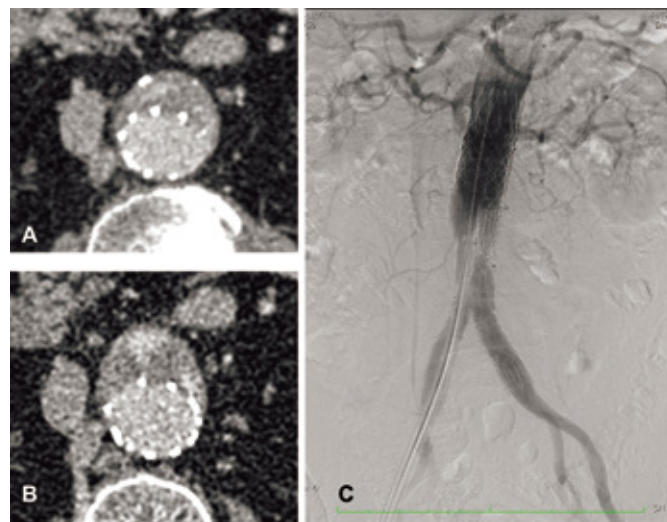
A, B: CTA revealing the presence of a type Ia endoleak. C: DSA revealing elimination of the endoleak by placement of a Palmaz XL stent.
